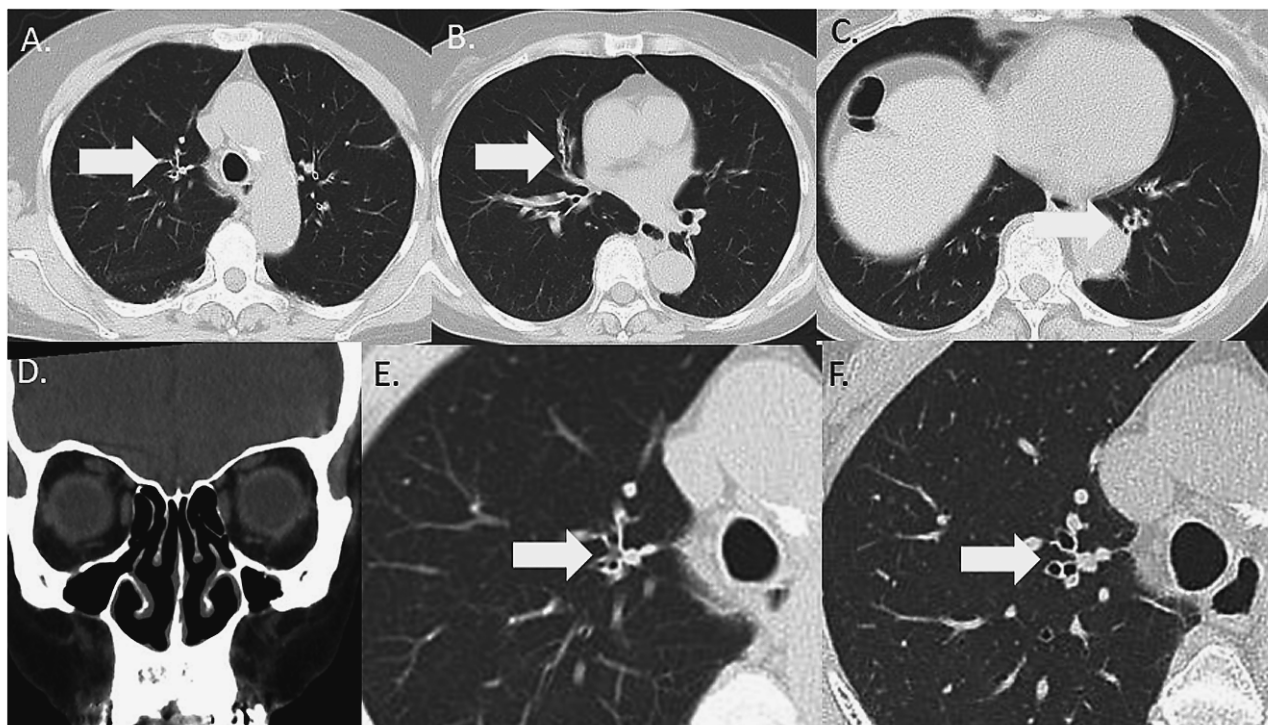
CT scans showing diffuse bronchial wall thickening, postinflammatory changes, and slight sinusitis. A–C: Lung window. D: Paranasal sinus window. CT scans of the lung window showing diffuse bronchial wall thickening before the start of the patient's tezepelumab (E) and at 1 month after the start of the tezepelumab treatment (F).
